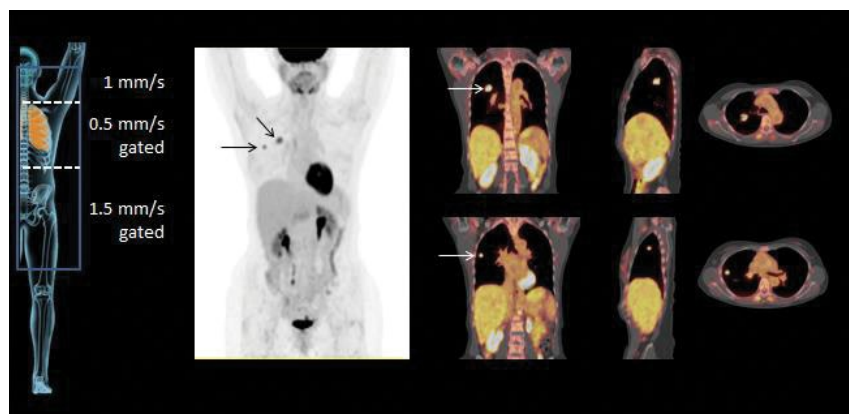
Whole-body PET/CT study demonstrates two hypermetabolic lung nodules.
